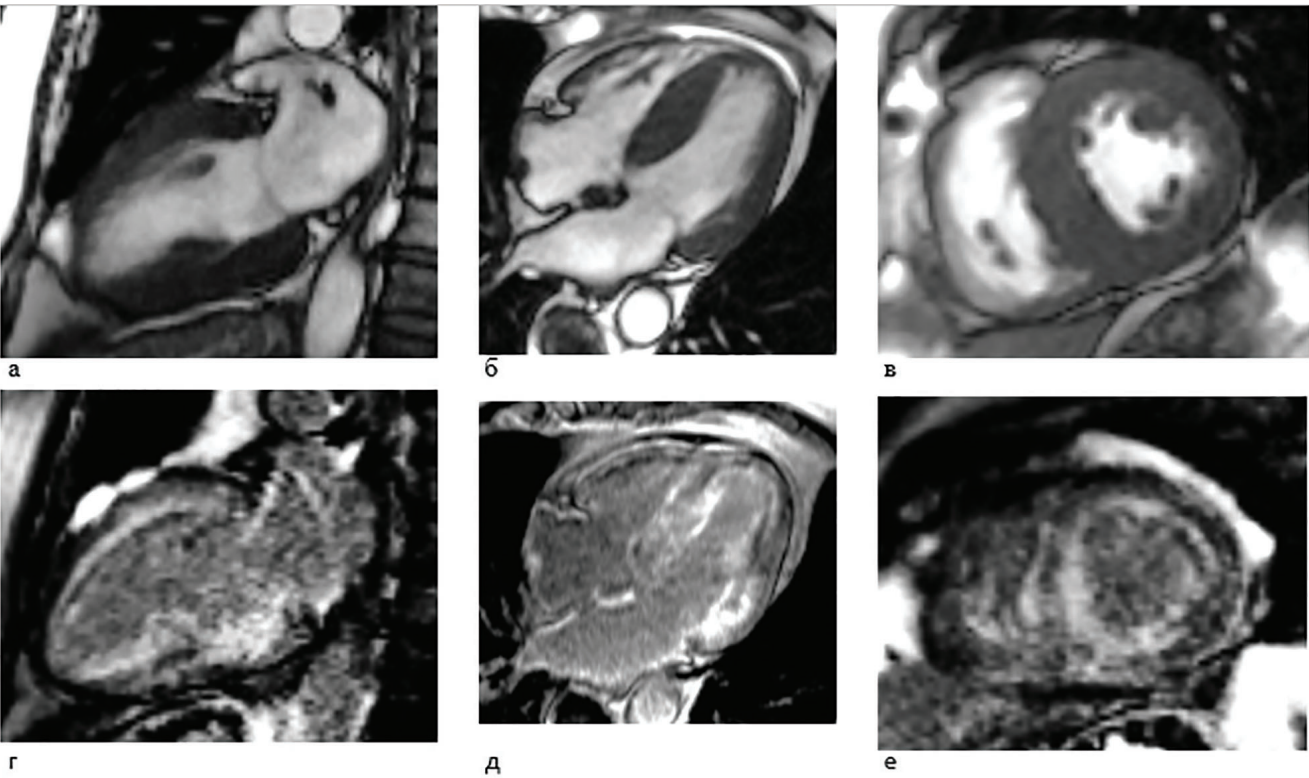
MRI of a patient with cardiac amyloidosis (photos from the archive Dr Ustyuzhanin D.V.)
